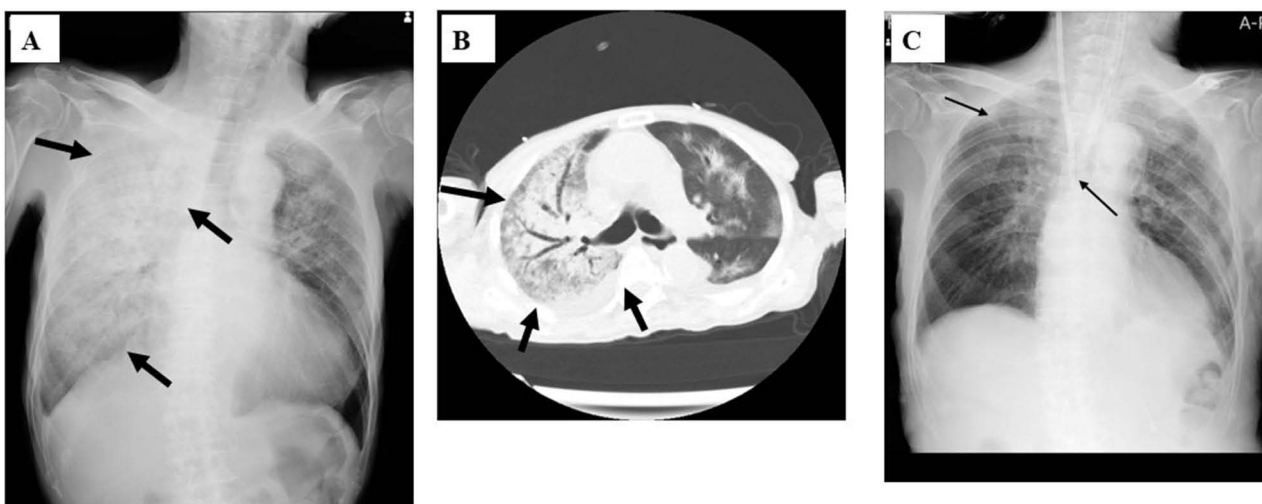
Chest X-rays (A and C) and computed tomography (B) of the Case 2 patient. At admission, there are abnormal shadows on the chest X-ray (A) and computed tomography (B), but these shadows improve after treatment (C). Arrows indicate the abnormal shadows.
